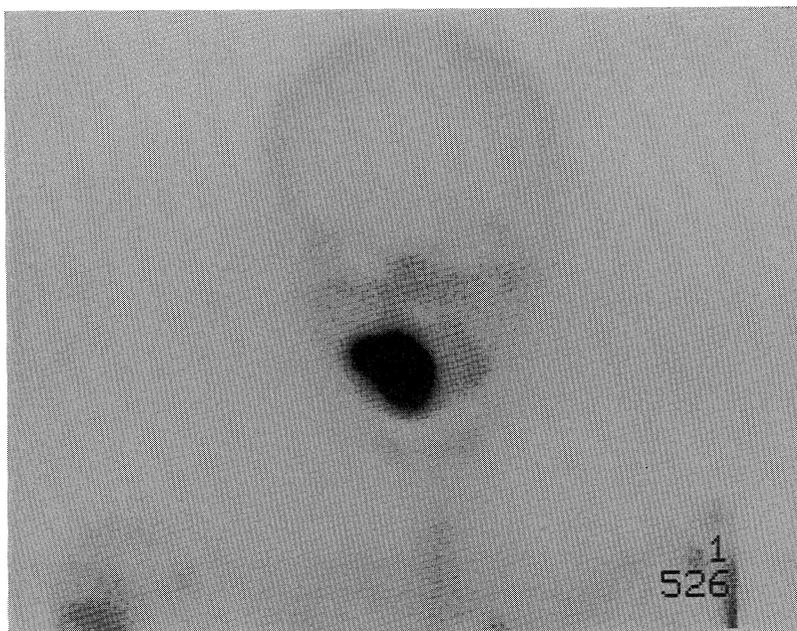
Bone scintigram (Anteroposterior view).
